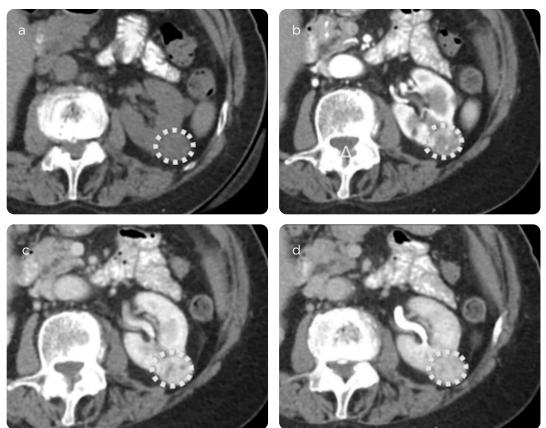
Solid oncocytoma, small, with heterogeneous enhancement. CT scan, a) phase without contrast medium, b) corticomedullary, c) nephrographic and d) excretory. Tumor less than 4 cms (dotted line). The corticomedullary phase (b) shows a central focal area of low density in the lesion. The nephrographic phase shows a low density focal area in the same region.
